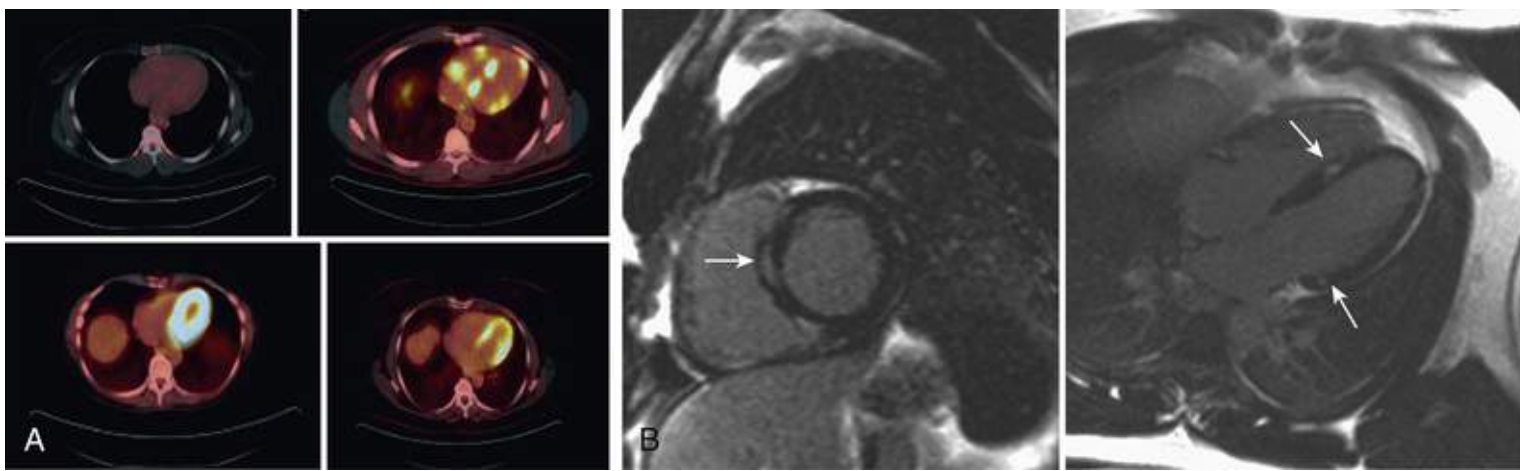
Sarcoidosis A, Four images show the pattern of ^{18}F -fluorodeoxyglucose uptake on positron emission tomography (PET) scan. B, Two cardiac magnetic resonance images show evidence of delayed gadolinium enhancement in the midwall of the left ventricle (*arrows*). (Modified from Hamzeh N, Steckman DA, Sauer WH, et al: Pathophysiology and clinical management of cardiac sarcoidosis. *Nat Rev Cardiol* 2015;12:278.)
